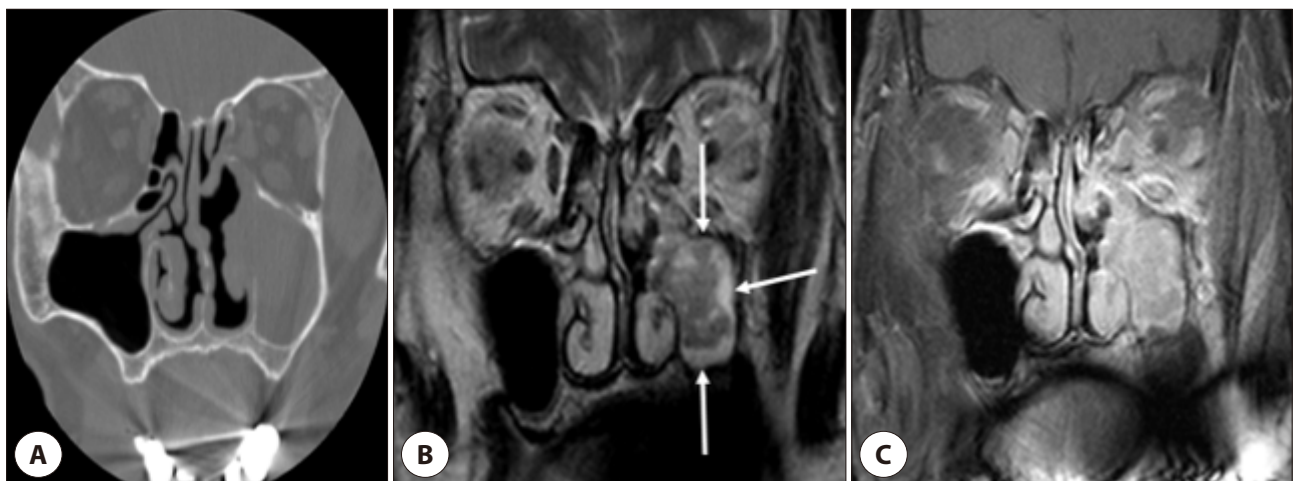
A 64-year-old male with inverted papilloma originating from the medial wall of the maxillary sinus. On CT (A), sclerosis is not observed at the medial wall. On coronal T2WI (B), peritumoral hyperintense layers are evident at the inferior, lateral, and superior portions (arrows) of the mass but not at the medial wall. On Gd-T1WI (C), contrast enhancement is seen in both the mass and the peritumoral edematous mucosa, obscuring the mass origin. T2WI: T2-weighted image, Gd-T1WI: Gd-enhanced T1-weighted images.
